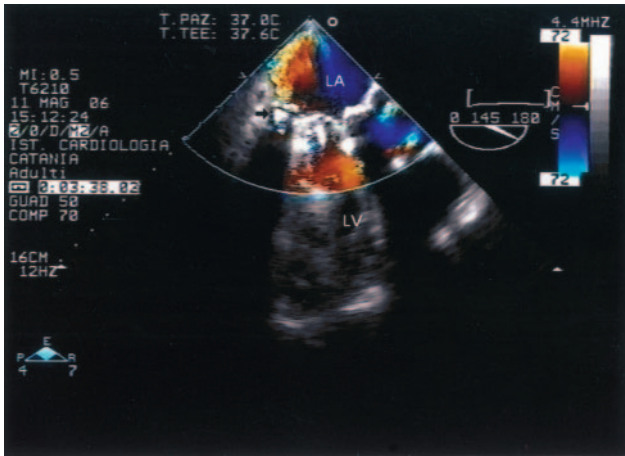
Transesophageal echocardiogram, long-axis view. The leak is localized posteriorly (arrow) and causes a severe regurgitant jet with “Coanda” effect. LA indicates left atrium; LV, left ventricle.
